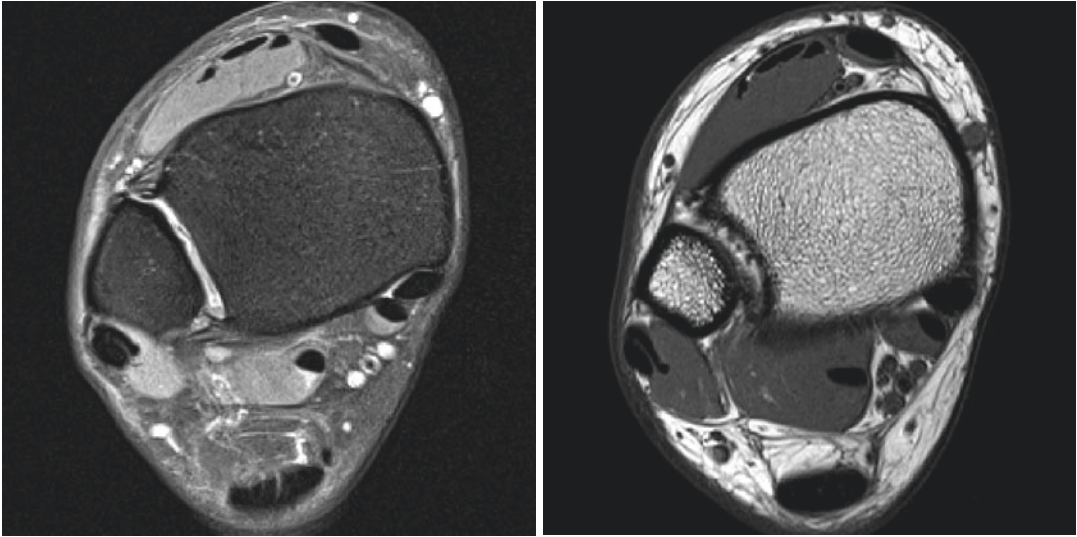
Two axial MR images of the ankle, indicating ligaments and the recess of the syndesmosis. This recess is cranially limited by the inferior edge of the interosseous
